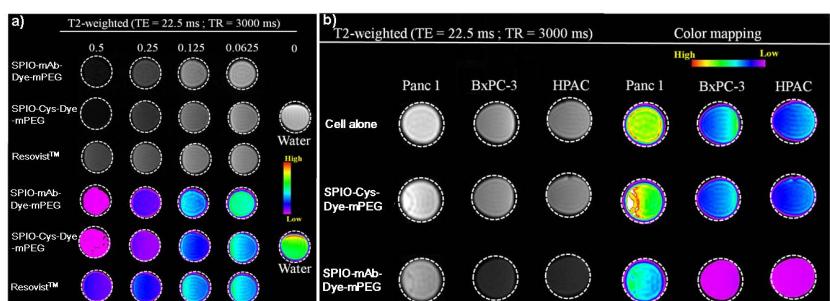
In vitro* T2-weighted MR images of SPIO-Cys-Dye-mPEG, SPIO-mAb-Cy777-mPEG and ResovistTM at different concentration mM of Fe. a) was show that compare the SPIO-mAb-Cy777-mPEG and ResovistTM. b) was show that analysis of specifically targeted on Panc 1, BxPC-3 and HPAC cell lines.
